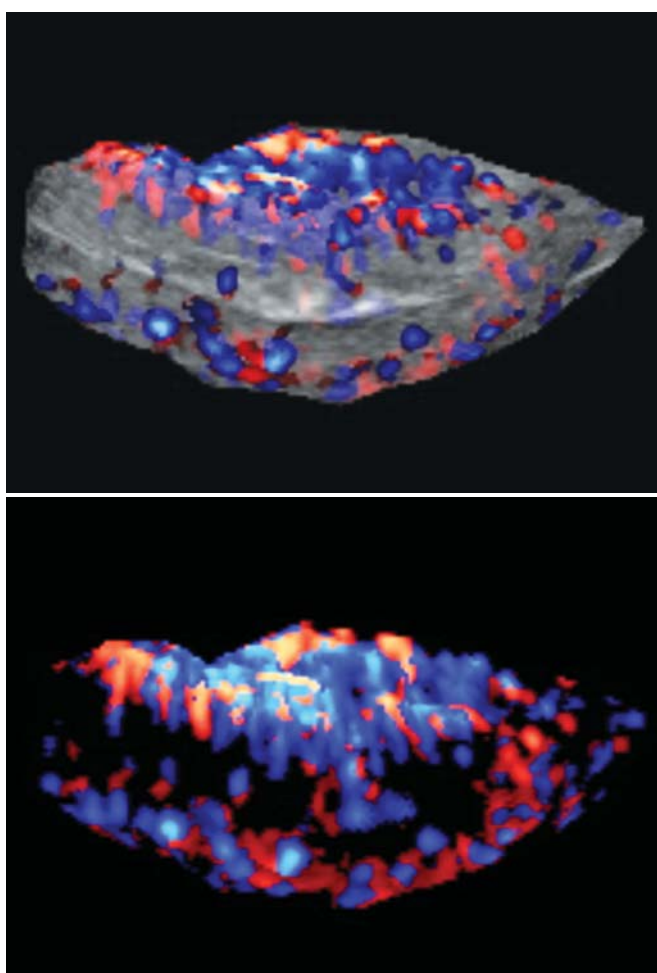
Glass body mode of endometrial 3D power Doppler vasculature
